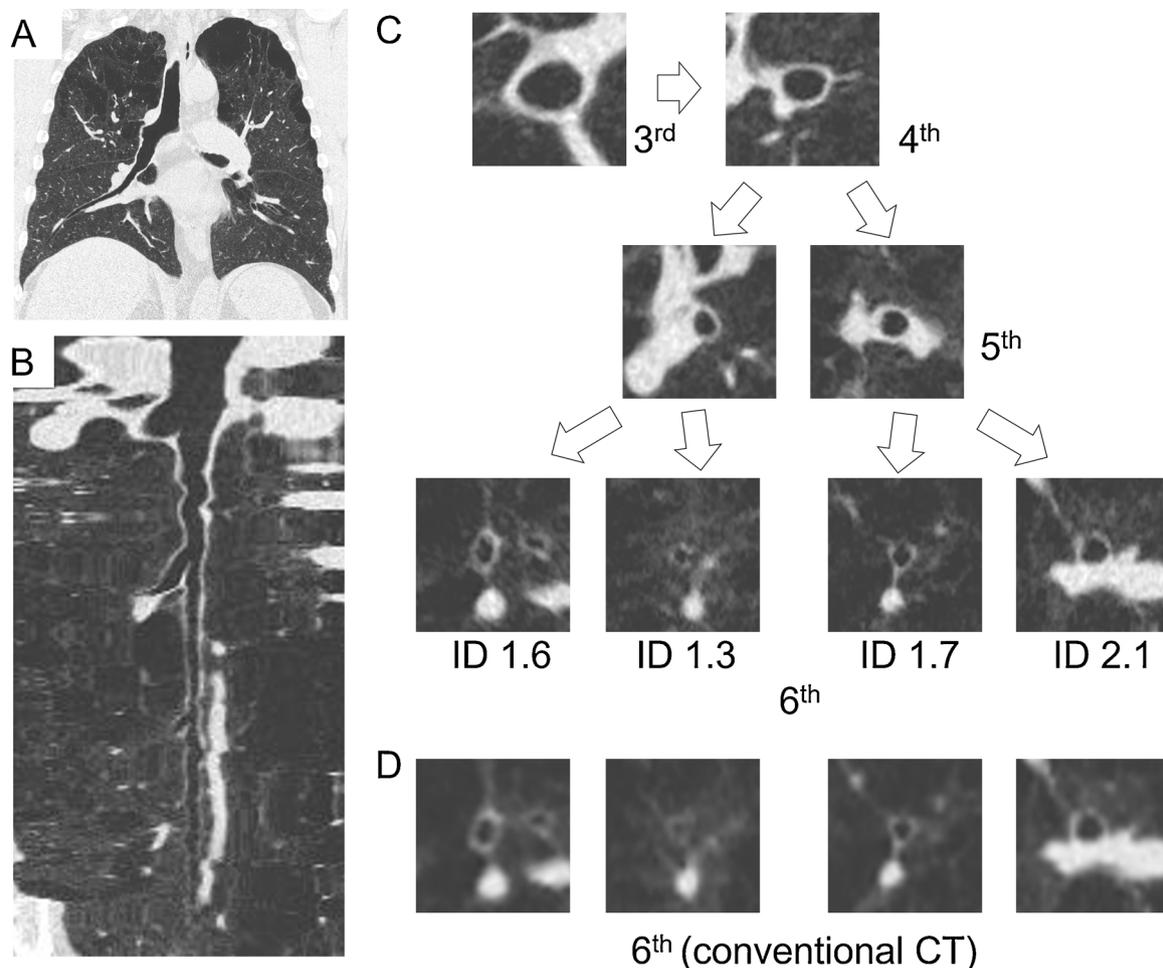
Examples of ultra-high-resolution CT scans showing the lumens of the 3rd to 6th generation airways in a patient with COPD. (A) An airway tree was extracted from the original ultra-high-resolution CT (U-HRCT) scan. (B) Multiplanar reconstruction was performed along the centre line of the extracted airway tree. (C) All airways located at the 3rd to 6th generations of the right apical and basal posterior bronchus (RB1 and RB10) were evaluated, and their lumen sizes were quantified. (D) Compared to the 6th generation airways on U-HRCT, these airways were less clearly visualized on conventional 512 × 512 CT with 0.5 mm slice thickness. ID = internal diameter (mm).
